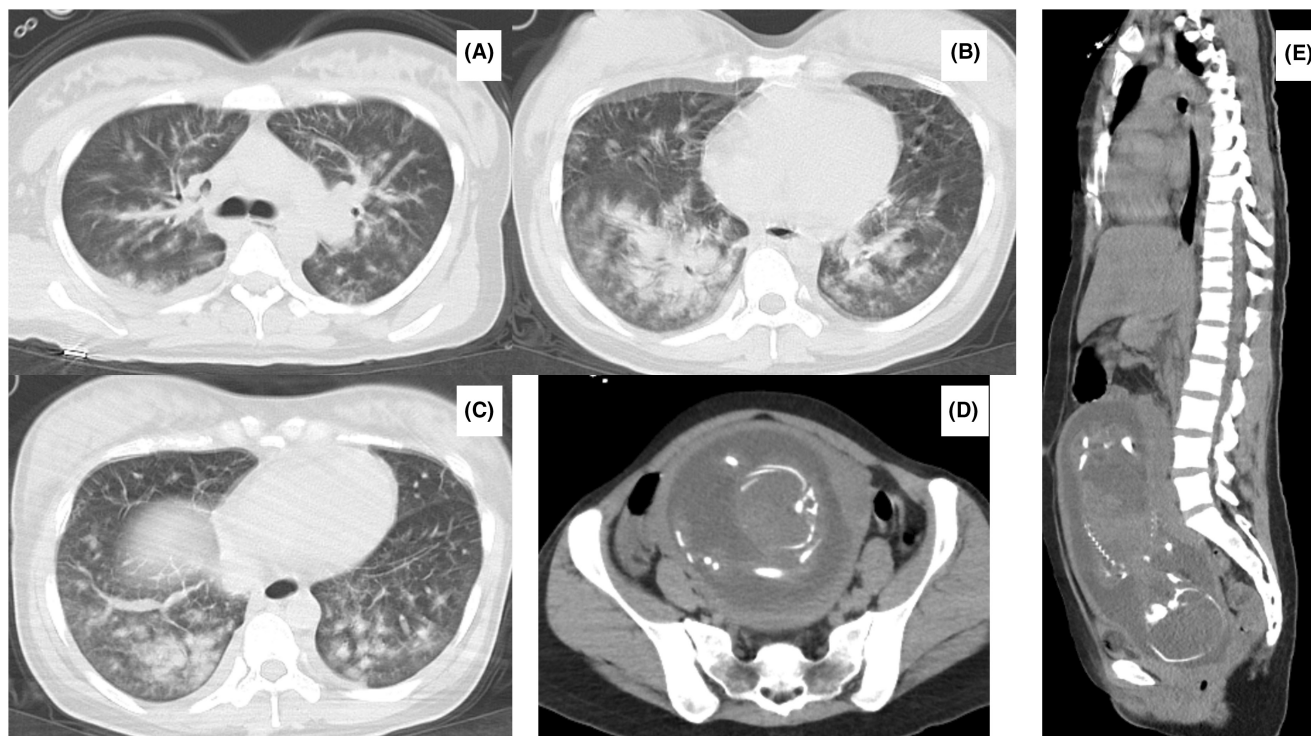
Computed tomography (CT) images on the day of hospital admission. (A–C) CT scan of the lungs shows bilateral consolidation with air bronchogram and infiltration, predominantly in the posterior area. (D, E) Abdominal CT scan shows no ascites, no abnormal inflammation, and the fetus in the uterus.
